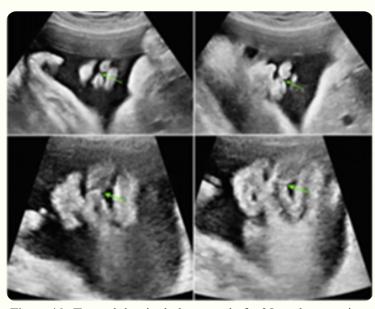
Transabdominal ultrasound of a 35 weeks gestation. Arrows indicate cleft lip site. Retrieved from Kim. D., 2015.
